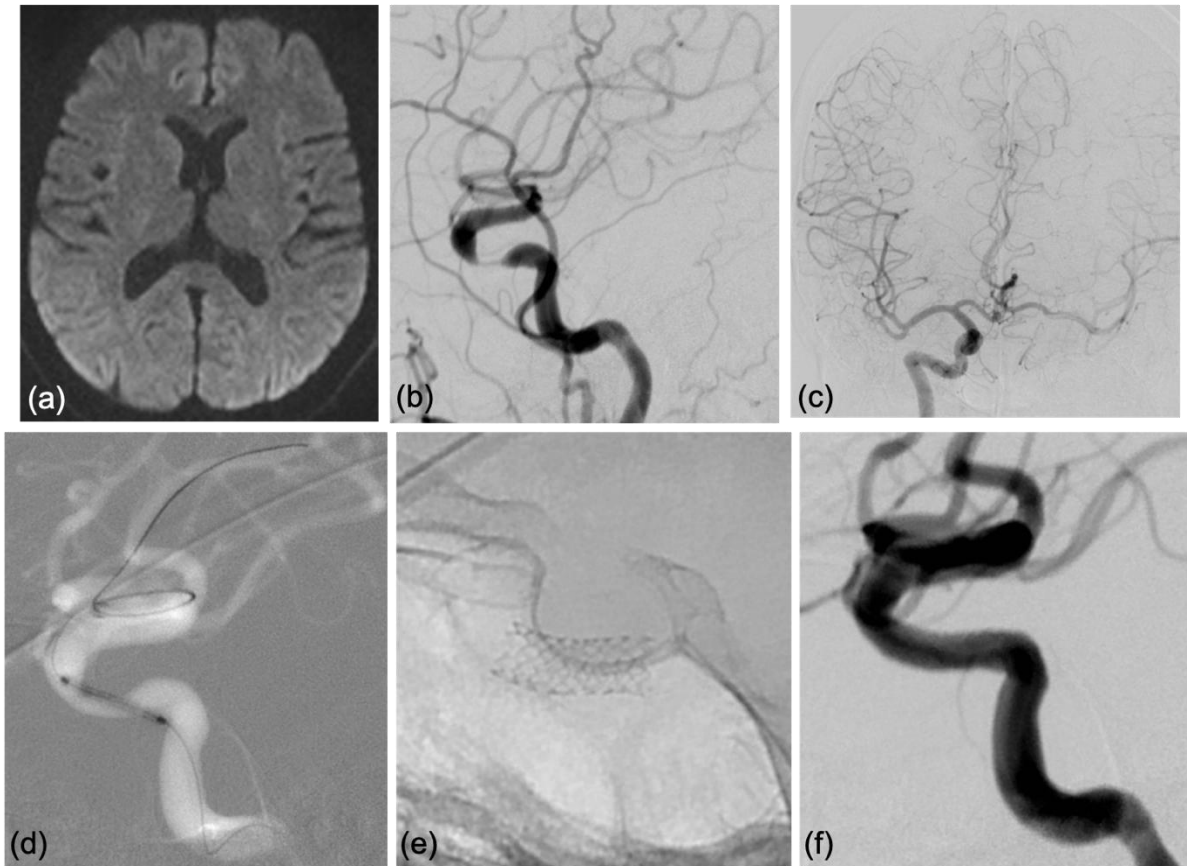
47- year-old male presented with repeated episodes of TIA (a) Axial DWI shows no evidence of any acute infarct. (b) Left ICA injection lateral view shows critical stenosis in the horizontal cavernous segment. (c) Right ICA injection AP view shows filling of the left MCA across anterior communicating artery. (d) Road map of left ICA injection showing deployment of stent across stenosed segment. (e) Fluoroscopic image shows stent open in-situ. (f) Post procedure check angiogram shows reconstitution of normal caliber of the left ICA.
